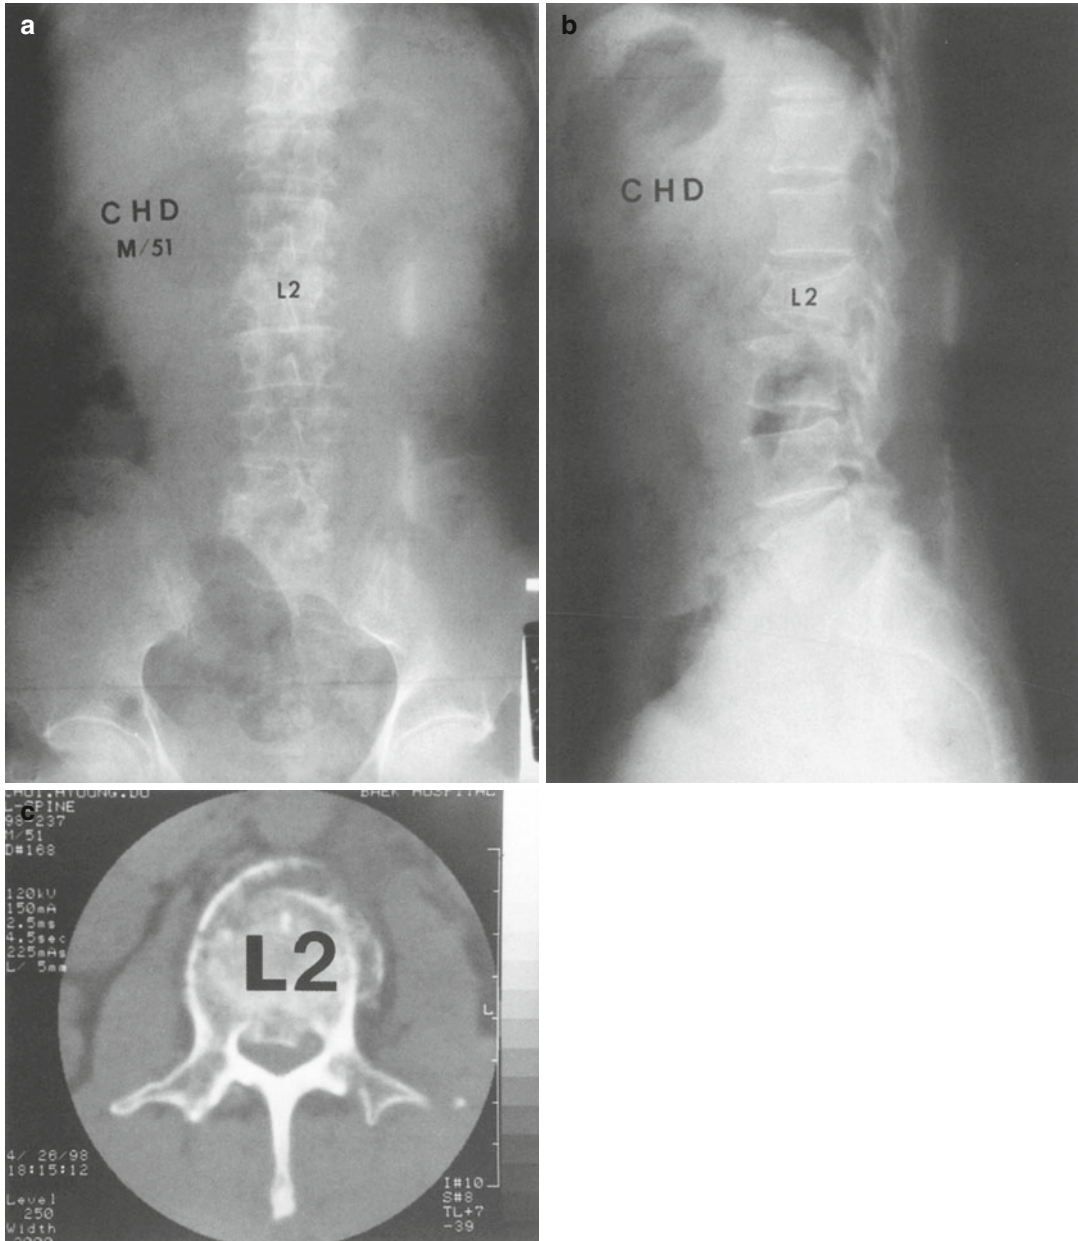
(a, b) A 51-year-old male with L2 unstable burst fracture. (c) Preoperative CT shows 40 % canal encroachment. (d, e) He was treated by posterior fixed moment arm cantilever fixation
